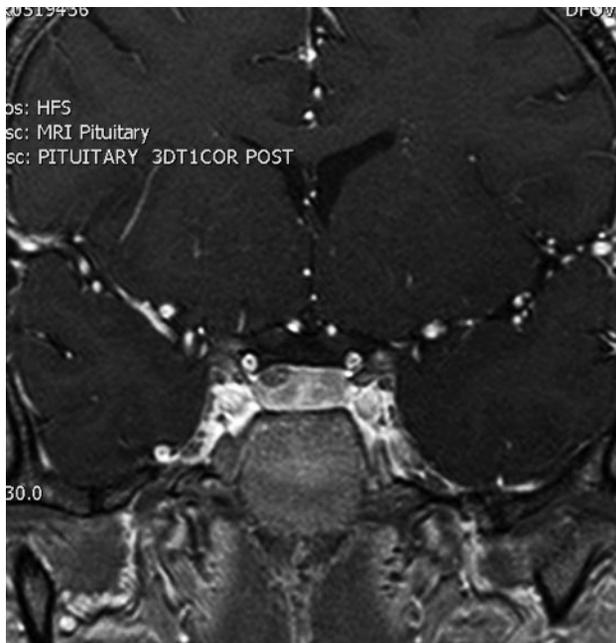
Pituitary spoiled gradient recalled acquisition (SPGR) MRI of a patient with pituitary microadenoma not visible on conventional MRI. Coronal postcontrast SPGR image of the pituitary demonstrates an abnormal area of diminished enhancement with respect to normal pituitary parenchyma in the superior and lateral margin of the anterior lobe on the patient's right (arrow). This abnormality represents an adrenocorticotropic hormone (ACTH)-secreting adenoma, which was confirmed at surgery. Compare this image with the image in Figure 1, which was obtained in the same patient after contrast using conventional spin echo imaging.
